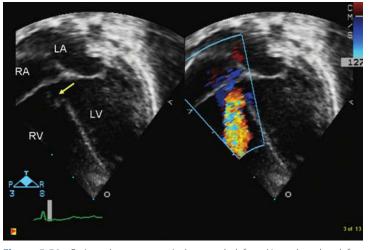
Perimembranous ventricular septal defect. Note that the defect (*arrow*) is located in the superior portion of the septum as seen on the apical fourchamber view (*left*). Color Doppler image (*right*) shows left-to-right ventricular shunt. LA, left atrium; LV, left ventricle; RA, right atrium; RV, right ventricle.
